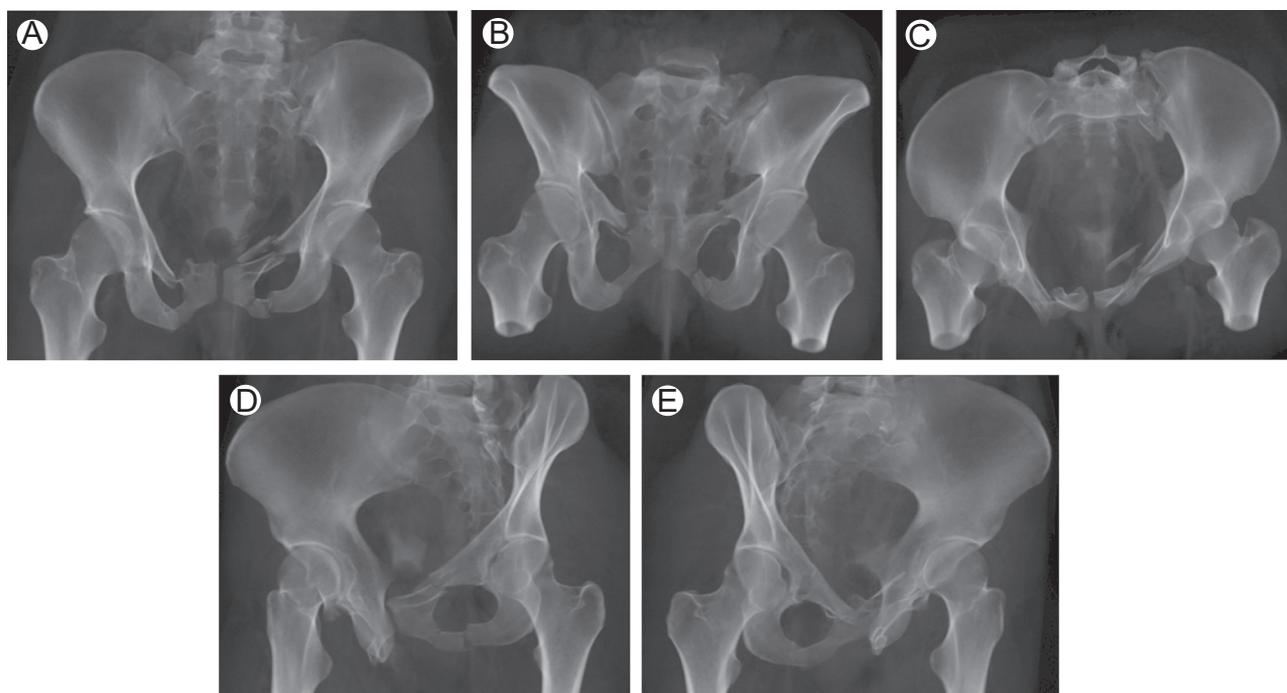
Reconstructed “ghost” images of the pelvis from CT data showing the 5 views in the pelvis series (A) AP, (B) outlet, (C) inlet, (D) Judet right posterior oblique, and (E) Judet left posterior oblique.
